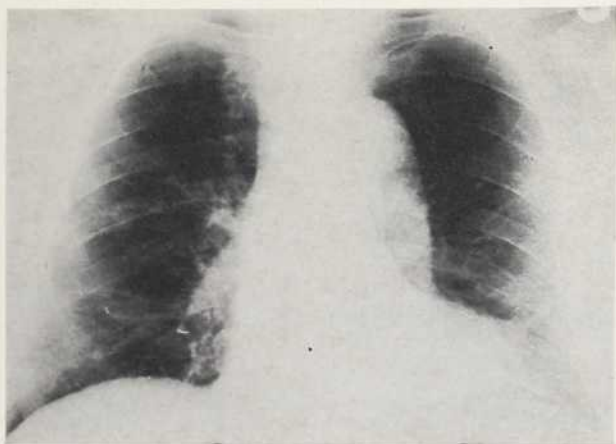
X-ray chest 8 months after operation (patient P.S.) shows the dilated arteriosclerotic heart of the recipient and the relatively normally-sized donor heart. The lungs are clear.
